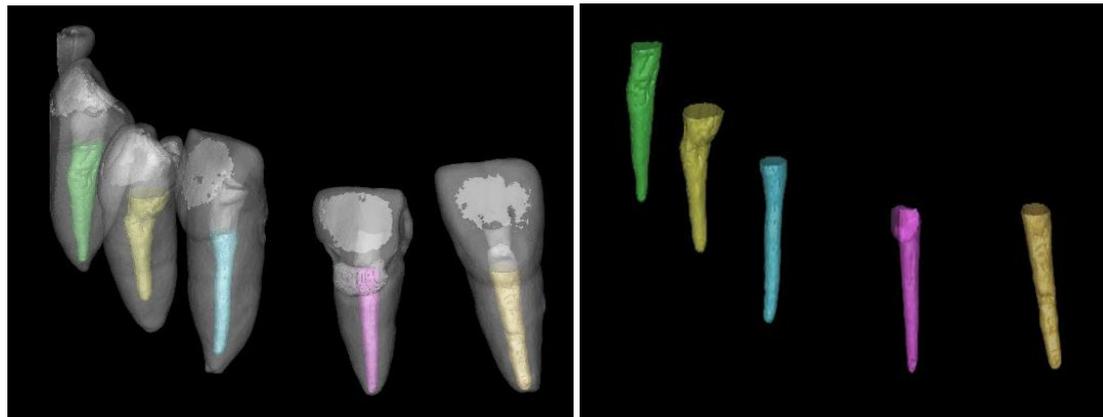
Showing CBCT scanning of root canal filling using lateral condensation technique
